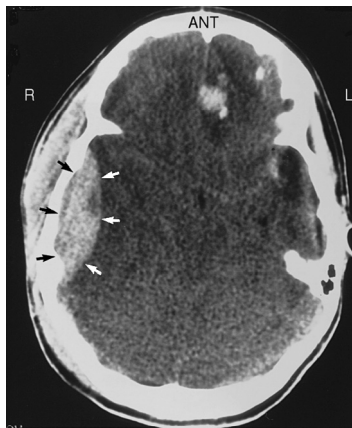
Epidural hematoma. In this patient, who was in a motor vehicle accident, a lenticular area of increased density is seen on a noncontrast axial computed tomography (CT) scan in the right parietal region. Areas of hemorrhage also are seen in the left frontal lobe. (From Mettler F. Essentials of radiology. 2nd ed. Philadelphia: Saunders, 2004.)
